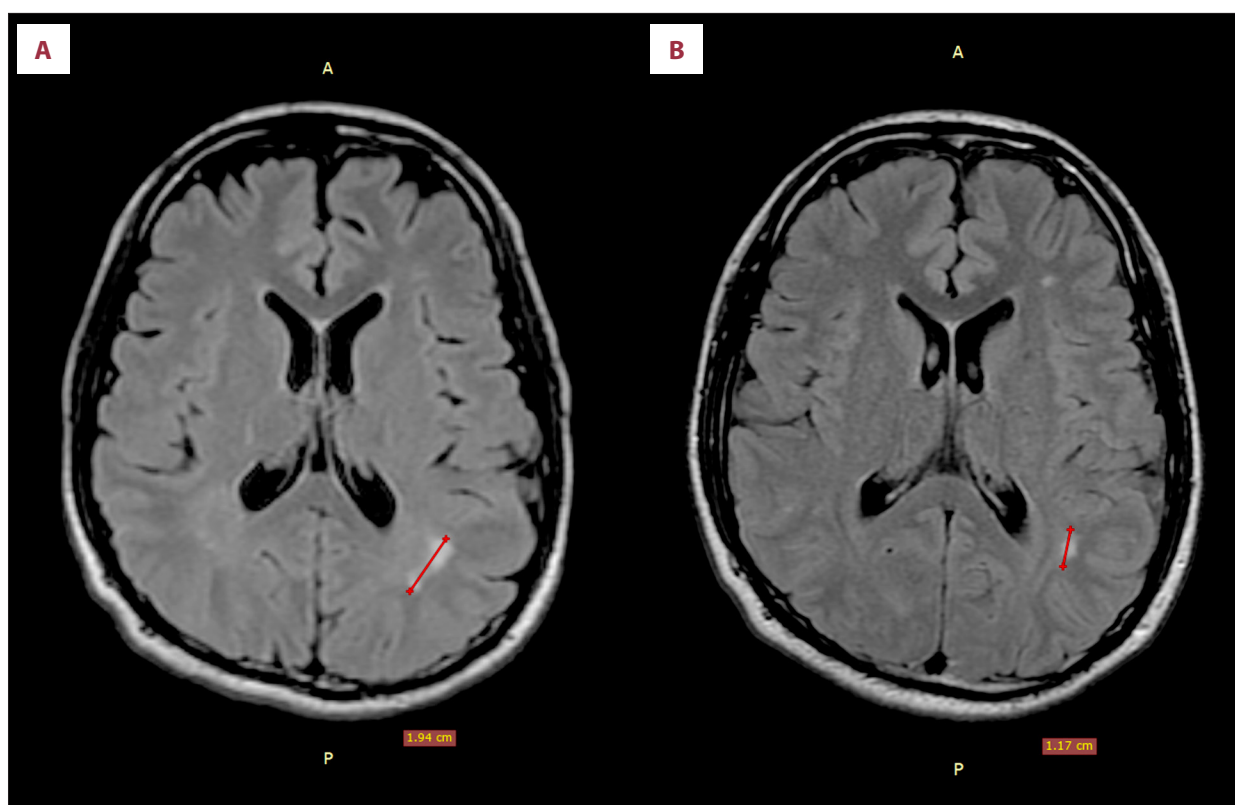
Brain magnetic resonance images of a 24-year-old man with vitreous *Onchocerca lupi* infection. (A) Hyperintense lesion in the white matter of the left parietal lobe on T2-weighted fluid-attenuated inversion recovery (FLAIR) sequences; (B) follow-up magnetic resonance image at 9 months demonstrating persistence of the lesion, with a decrease in size.
